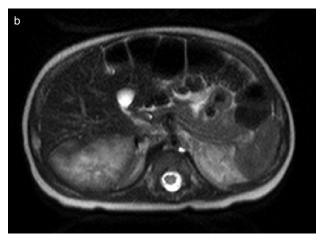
MR images at 2 months of age a: The leision was demonstrated as hypointensity at posterior lobe of liver in T1-weighted MR images.
